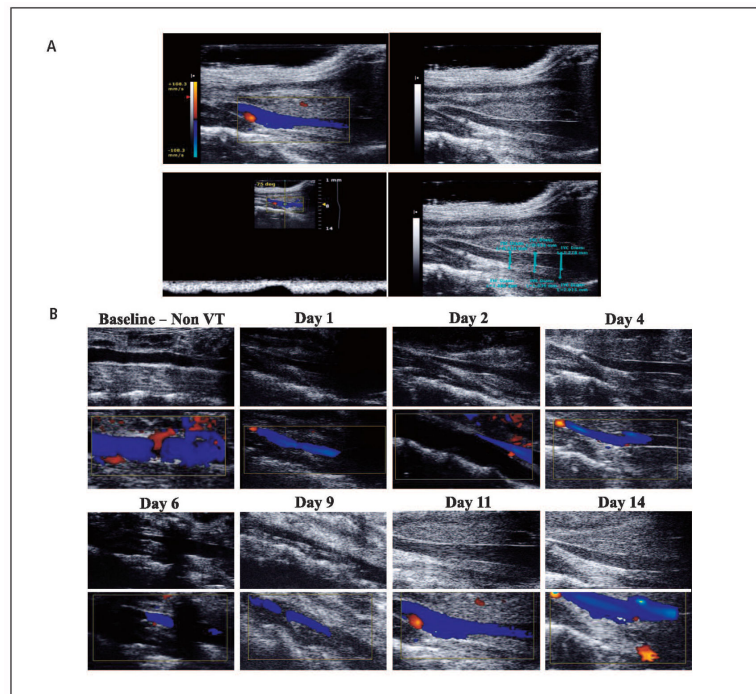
Ultrasound assessment and follow-up
